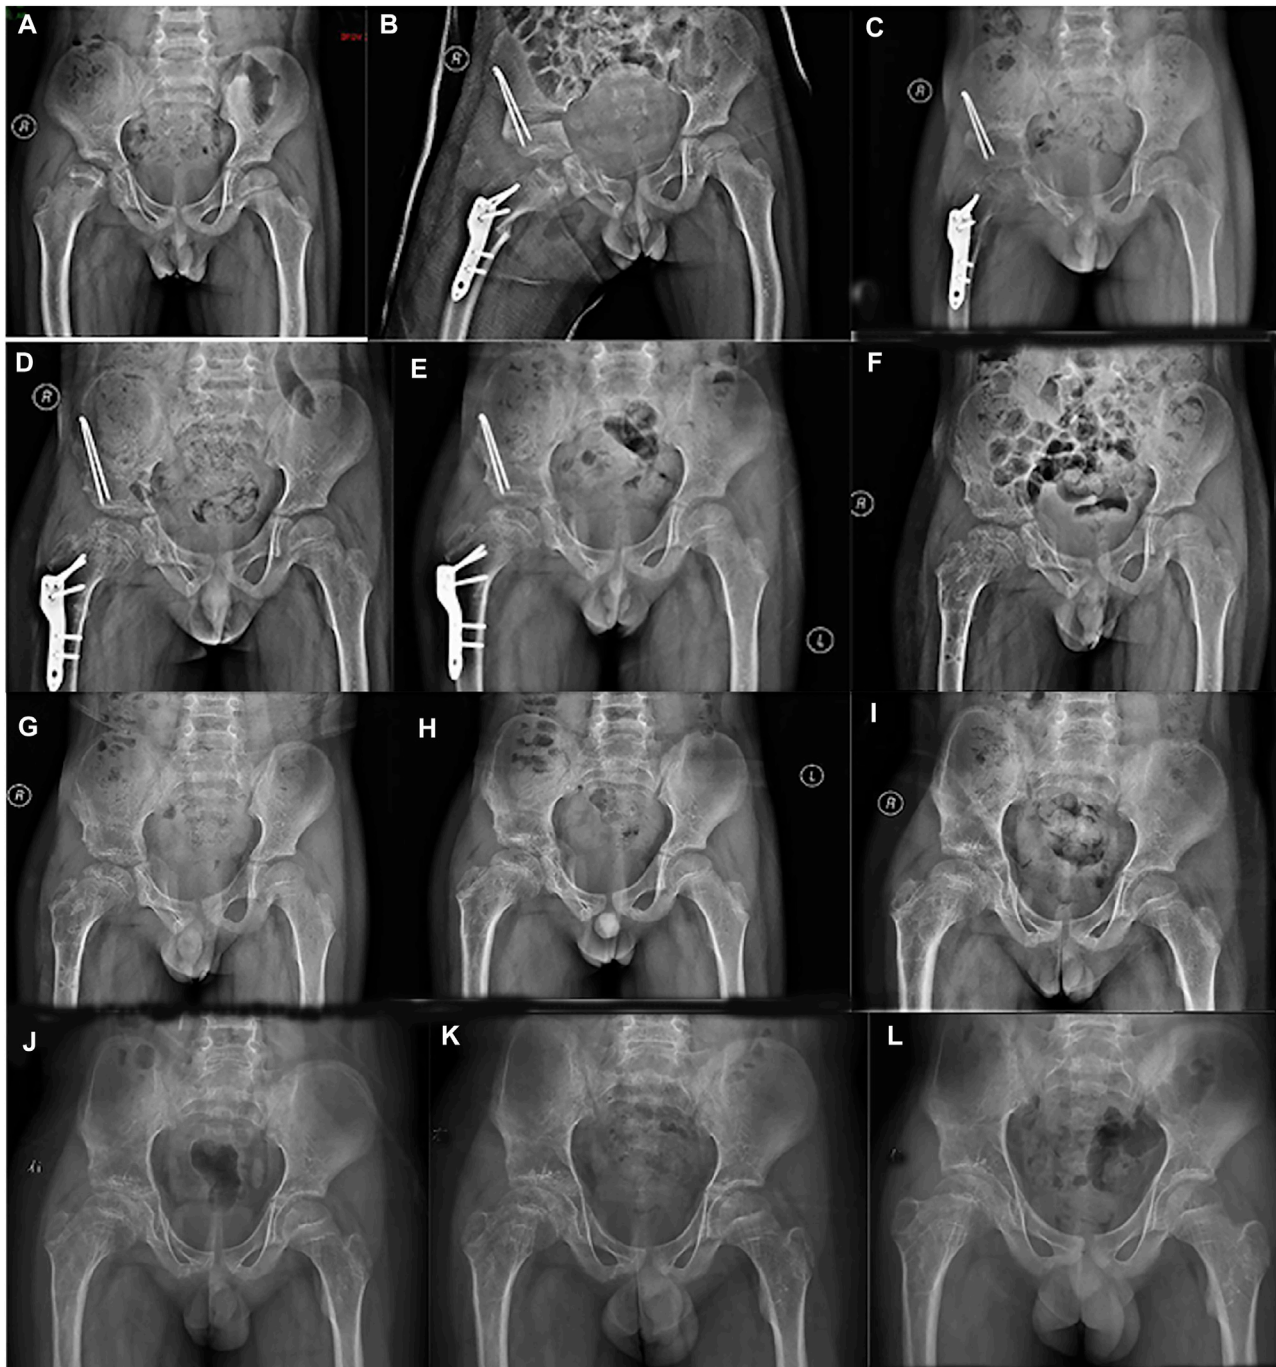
Series radiographs of pelvis from a boy with Perthes disease presentation. (A) Pelvic radiograph of a 7.5 years old boy (March 2016). (B) Postoperative pelvic radiograph (March 2016). (C) 4 months after operation (July 2016). (D) 7 months after operation (October 2016). (E) 11 months after operation (February 2017). (F) 12 months after primary operation, and 1 month after implant removal (March 2017). (G) 3 months after implant removal (April 2017). (H) 1 year after implant removal (March 2018). (I) 2 years after implant removal (January 2019). (J) 3 years after implant removal (November 2019). (K) 4 years after implant removal (October 2020). (L) 5 years after implant removal (January 2022).
